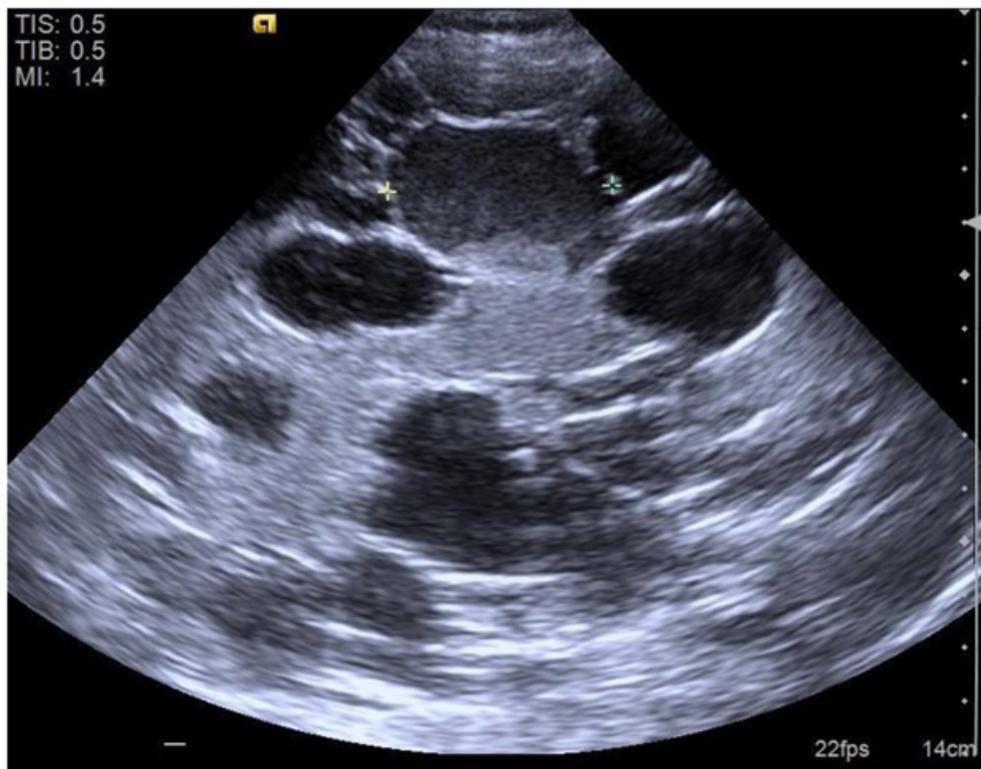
Liver ultrasound of an ADPKD patient with PLD. A cyst 4.2cm at left lobe showed hyperechoic sludge with glittering spots.
